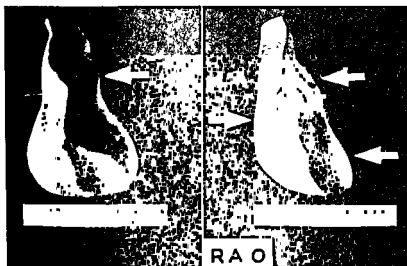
40 yrs, M Emphysema. Roentgenologic, volumetric reconstruction. *Ant view*: globular heart without enlargement, prominence of pulmonary conus and artery (arrow). *Rt ant obl view*: normal findings along dorsal border, no enlargement of lt atrium (lt arrow). Cranial portion rt ventricle prominent (conus arteriosus), (lt upper arrow). Rt ventricle, caudal portion (lt. lower arrow). (Courtesy Prof Dr G G Palmieri, Bologna, Italy)
